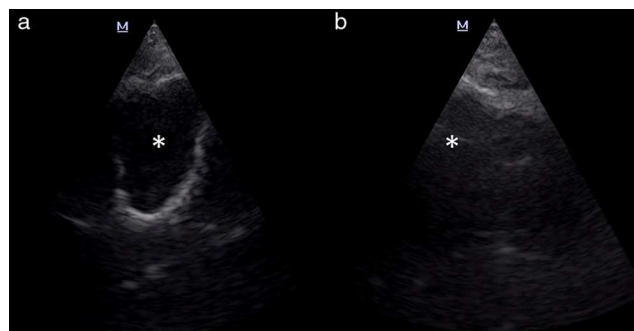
Comparative maxillary sinuses ultrasound, phased-array probe, right (a) and left (b), demonstrating a complete sinusogram on the right in contrast with a normal air-artifact without visualization of the sinus walls on the left. Asterisks: maxillary sinuses.
